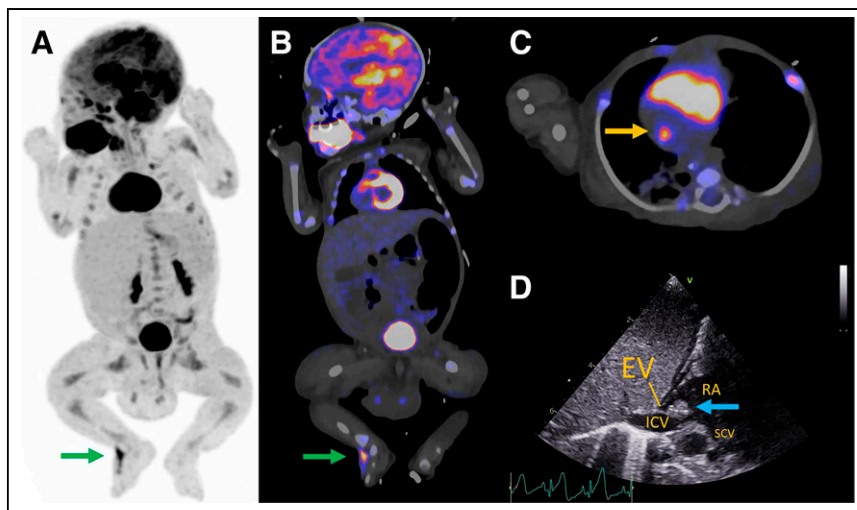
10-wk-old baby presenting with *Staphylococcus aureus* sepsis of unknown origin underwent total-body ^{18}F -FDG PET/CT imaging, which was performed in 3 min (1 bed position) without sedation on Biograph Vision Quadra system (Siemens Healthineers) using only 12 MBq. His medical history consisted of several congenital defects, including Fallot tetralogy and jejunal atresia. Two infectious foci were detected: at dorsum of right foot (A and B, green arrows) around intravenous access line, and at bottom of right atrium near entrance of inferior caval vein (C, arrow). Reactive bone marrow uptake is also visible (A). Ultrasound of foot revealed subcutaneous abscess, which was drained; culturing detected *S. aureus*. ^{18}F -FDG uptake in heart corresponded with solid, echodense structure suggestive of thrombus or vegetation. This is seen on transthoracic echocardiography (D, arrow) at eustachian valve (usually absent by adulthood), indicative of possible endocarditis. Patient improved under antibiotic therapy. (Reprinted with permission of (124).)
